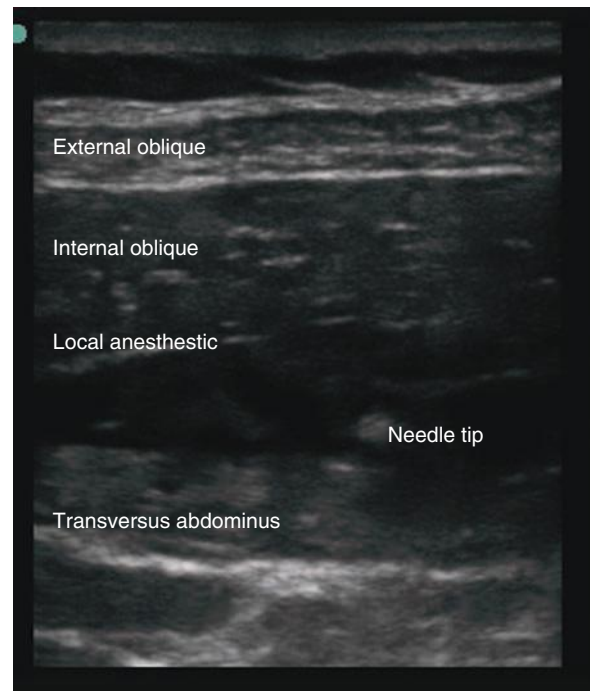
Ultrasound image of local anesthetic above the transversus abdominis.
